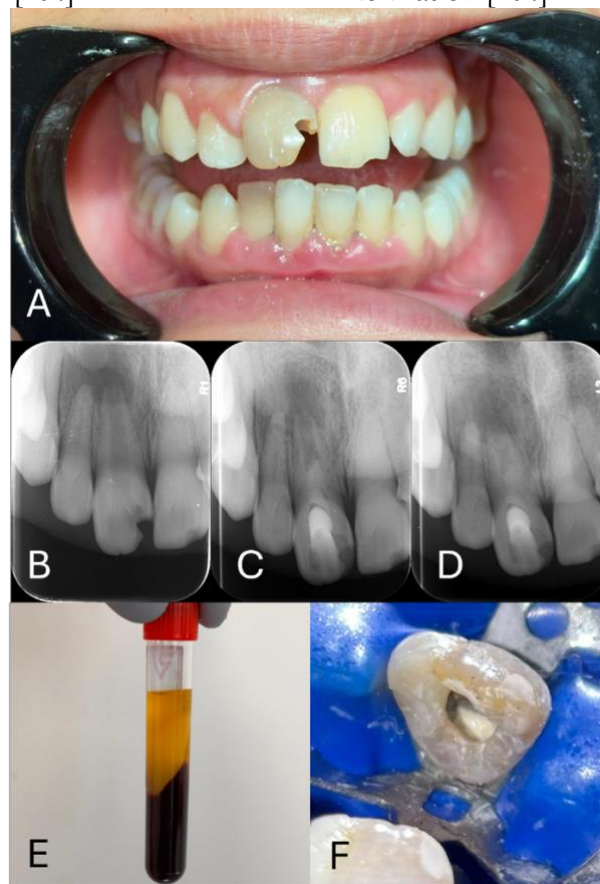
Clinical and radiographic views of a regenerative endodontic treatment case. (A) Preoperative intraoral view showing coronal fracture. (B) Initial periapical radiograph prior to treatment. (C) Immediate postoperative radiograph following regenerative procedure. (D) Three-month follow-up radiograph demonstrating progressive periapical healing. (E) Platelet-rich fibrin (PRF) tube prepared for use as a biological scaffold. (F) Intraoral view following placement of Biodentine as a coronal barrier.
